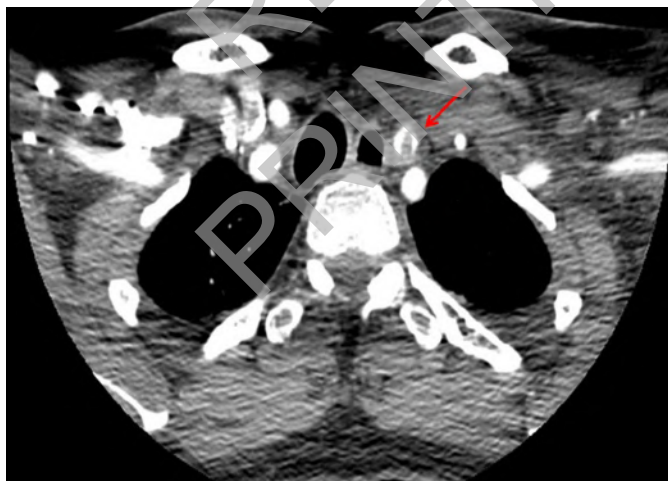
Left Carotid Artery Dissection. The admission CT scan showed dissection of the origin of the left common carotid artery with stenosis of the lumen.
